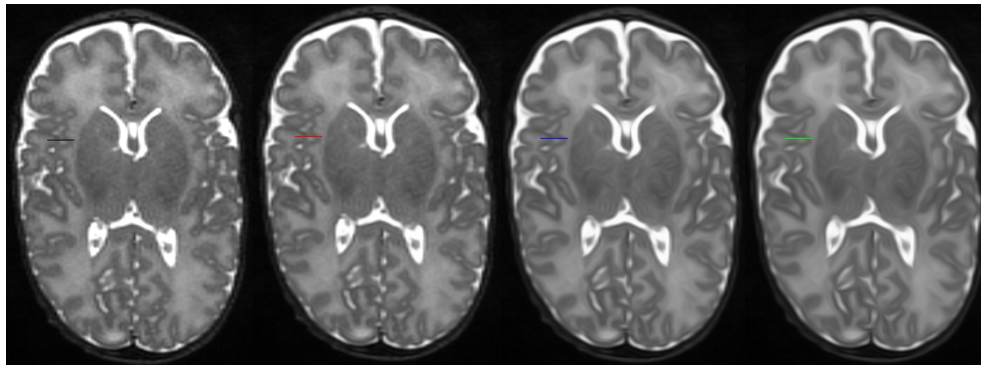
Left image shows an example of the original MR image, the other images are the results after applying the CED filter using different diffusion parameters; second image: $t=1$; third image: $t=5$; fourth image: $t=10$.
